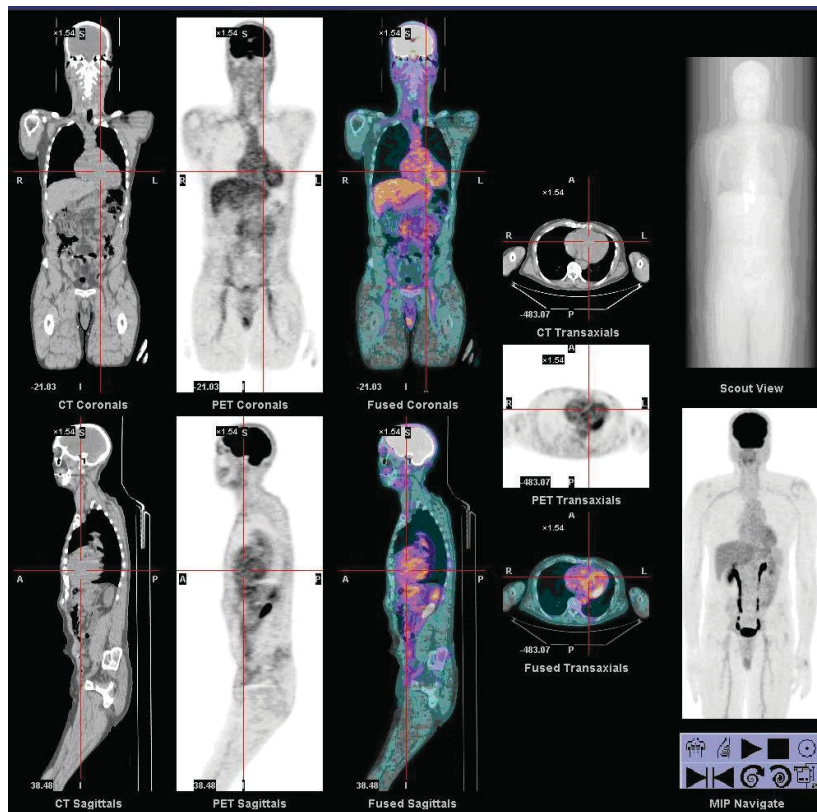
Example of PET-CT exam
